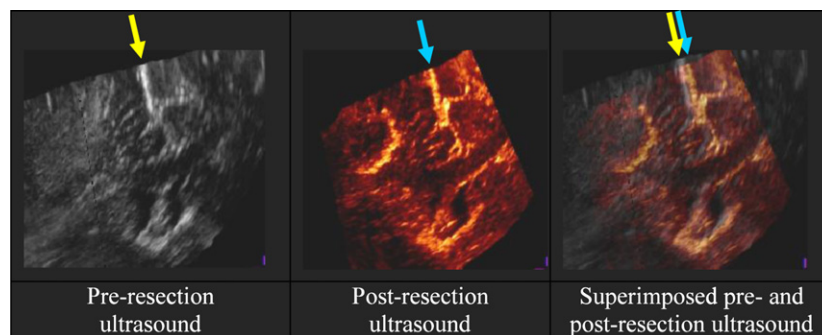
Preresection (*gray shades*) and postresection (*warm shades*) ultrasound images. *Arrows* indicate the falx and show its misalignment in images taken at different time points (*far right*).
